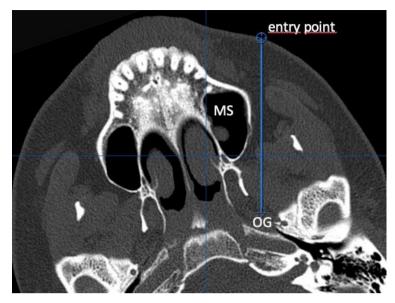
CT reconstruction of the trajectory used to target the otic ganglion (OG) in one of the patients treated in paper 4. MS: maxillary sinus. A modified version of this imaged has been published by the author of this Thesis (139).
